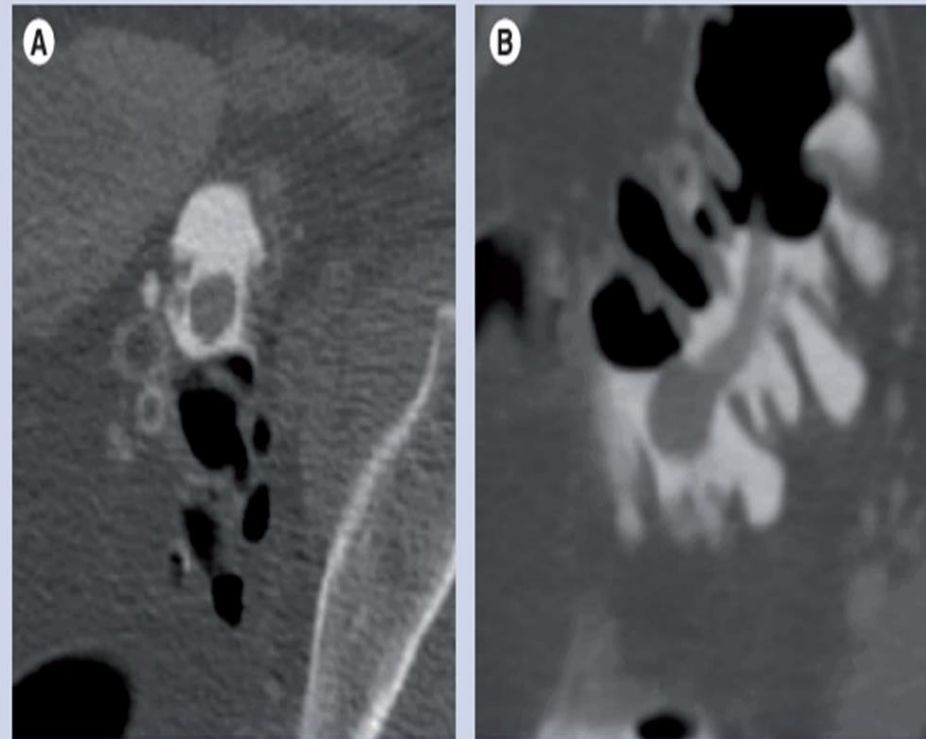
CT colonograph of the colon of a 55-year-old female. Shows a peduncolated polyp in the sigmoid colon. 2D axial CT colonography prone view (A) and 2D axial supine view (B). The polyp appears submerged in the tagged iodinated residual fluid.
